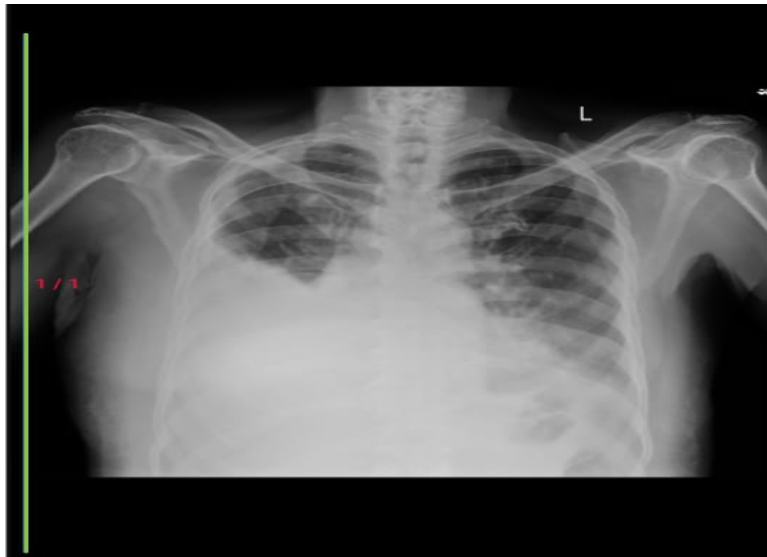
Chest X-ray showing right sub-pulmonic pleural effusion.
